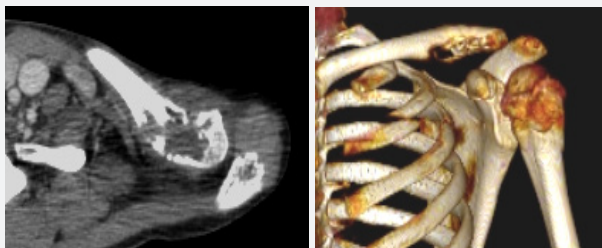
Cortical destruction in the bone seen on axial slice CT and 3-dimensional CT
